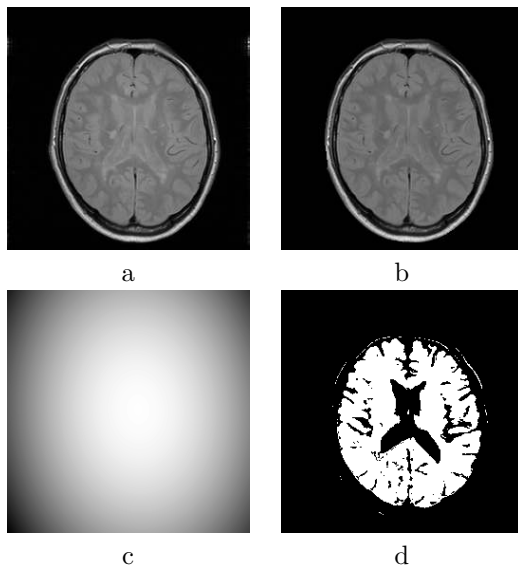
Correction of a 3D MRI dataset taken from a Multiple Sclerosis study using spin-echo dual-echo imaging. A single slice of the first echo is shown (classes white and gray matter; Legendre polynomials up to the second degree). a: Uncorrected volume, b: Corrected volume, c: Calculated bias field. d: Class-mask. The bias correction is small but significantly improves gray/white matter separation (see Figs 15, 16).
